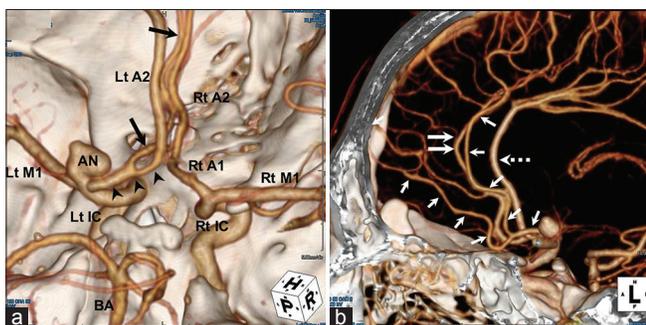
(a) Superoinferior view of the three-dimensional computed tomography angiogram, showing a saccular aneurysm arising from the left internal carotid artery bifurcation and an anomalous cortical branch originating from the left A1 segment of the anterior cerebral artery (black arrowheads). The anomalous artery runs anteromedially and then ascends superiorly and parallel to the right A2 segment of the anterior cerebral artery (black arrows). (b) Left lateral view of the three-dimensional computed tomography angiogram, showing the arterial course of an anomalous cortical branch originating from the left A1 segment of the anterior cerebral artery (white arrows) and its relationship to the bilateral A2 segment of the anterior cerebral artery. The artery runs parallel to the right A2 segment of the anterior cerebral artery (white double arrows). The left A2 segment of the anterior cerebral artery supplies the bihemispheric branches (white dotted arrow). A1: A1 segment of the anterior cerebral artery, A2: A2 segment of the anterior cerebral artery, BA: Basilar artery, IC: Internal carotid artery, Lt: Left, M1: M1 segment of the middle cerebral artery, Rt: Right, AN: Aneurysm
